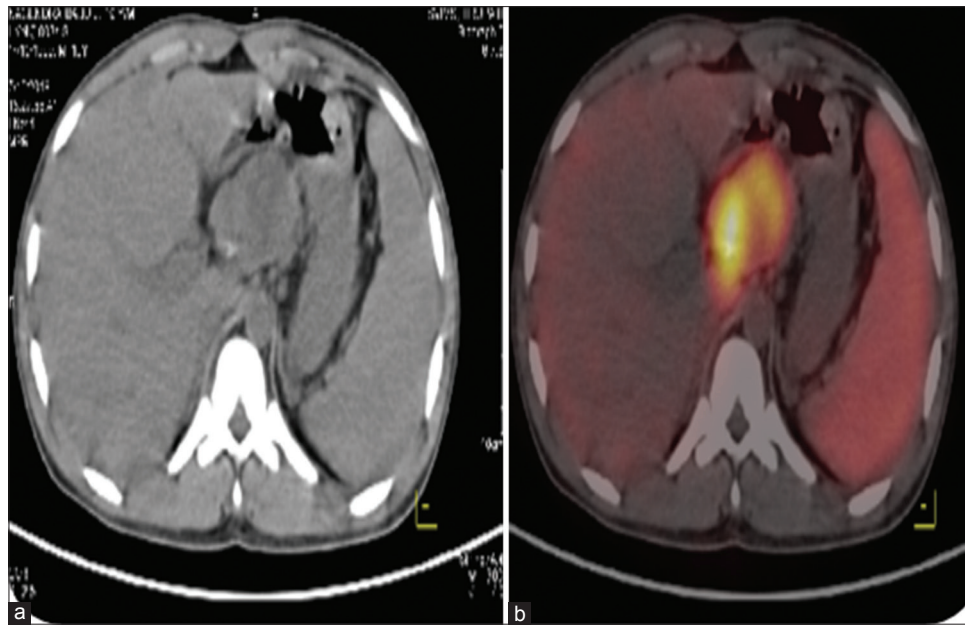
Axial computed tomography (a) and fused positron emission tomography/computed tomography (b) images showing increased radiotracer uptake in the soft-tissue density lesion arising from the head of the pancreas
